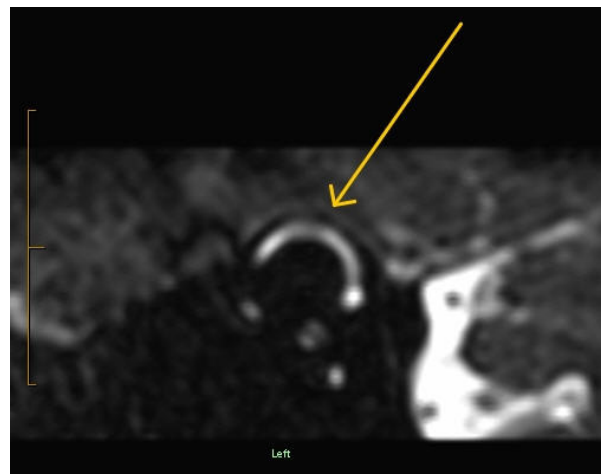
Right coronal MRI scan. Arrow indicates the closeness of dura to superior canal perilymph.
